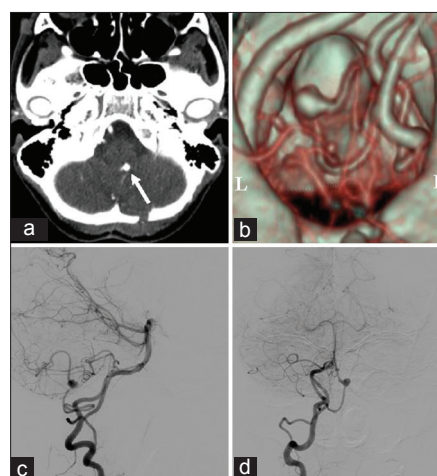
Radiological findings of aneurysm. (a, b) A three-dimensional computed tomographic angiogram showing that the nodule was a right posterior inferior cerebellar artery aneurysm (arrow). R, right and L, left. (c) Lateral and (d) anteroposterior digital subtraction angiographic views confirming the fenestrated vertebral artery and the aneurysm between the infratonsillar and supratonsillar loops
